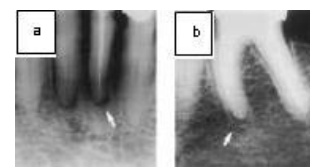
Example of periapical radiolucency [29].
